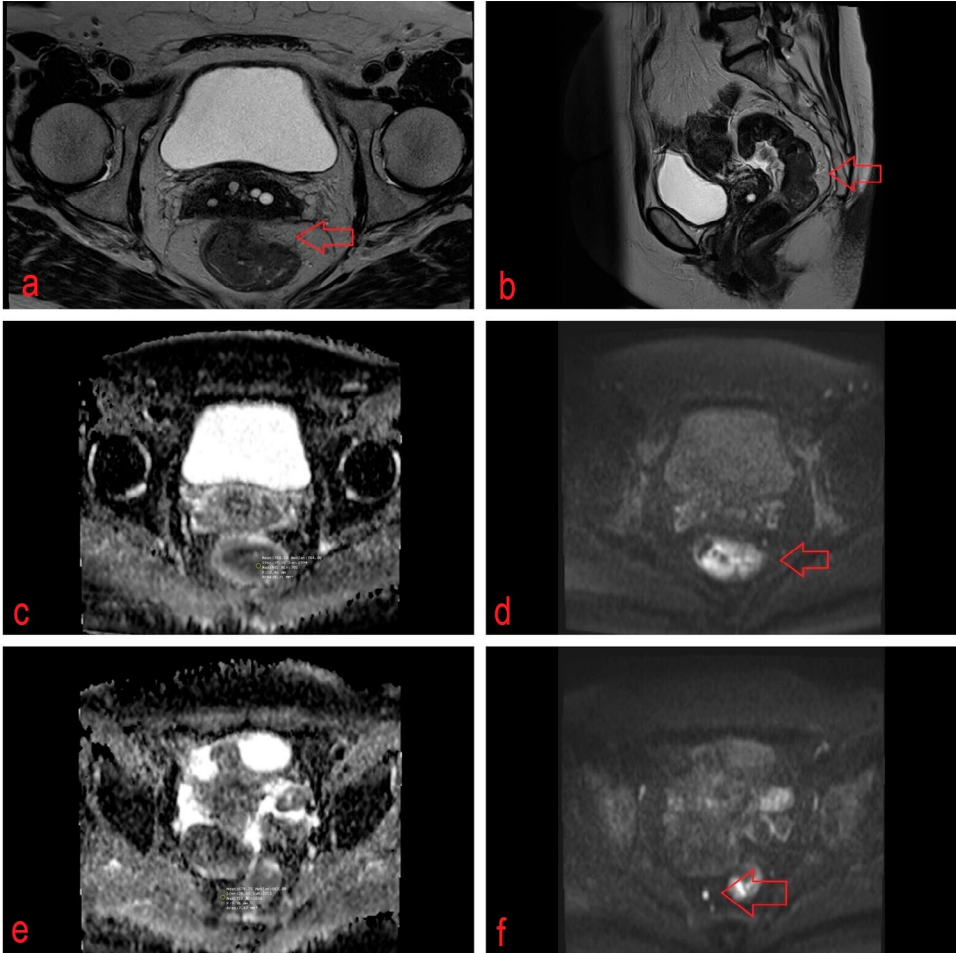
MRI scans of rectal cancer, staged as T3bN2, involving the mesorectal fascia and multiple enlarged mesorectal lymph nodes
